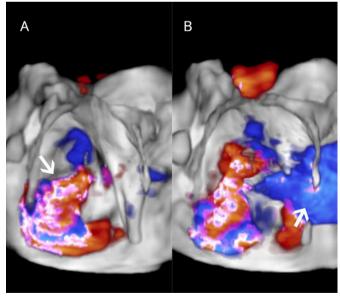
Three-dimensional echocardiogram image of the mitral valve from the left atrial perspective. Color Doppler demonstrates valve regurgitation (arrow) (A) and left-to-right shunt through the atrial septal defect (arrow) (B).
